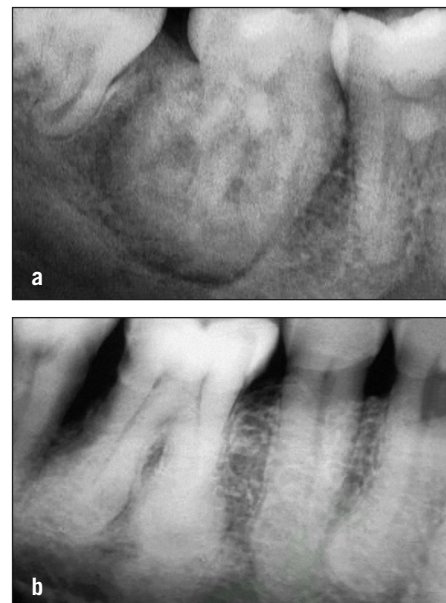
Comparison of radiographs of cementoblastoma (a) and hypercementosis (b).
